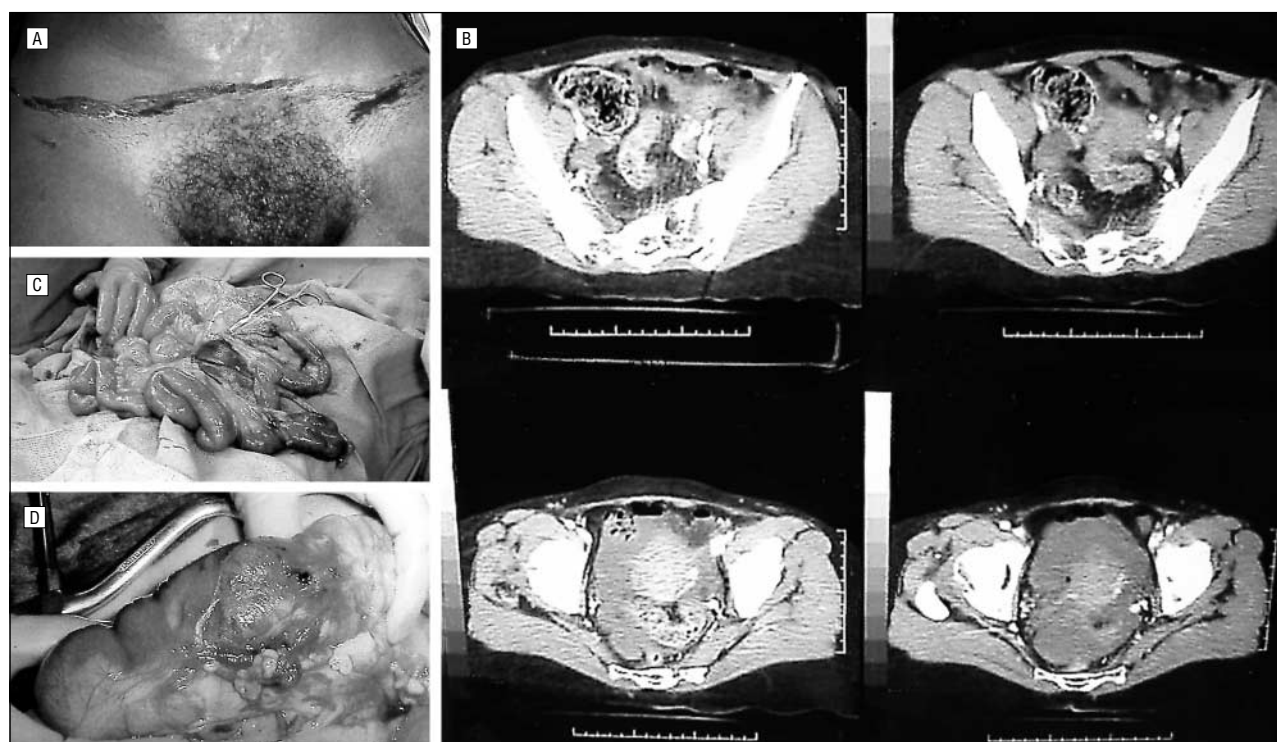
Patient with negative focused abdominal sonography for trauma scan result. A, Abdominal seat belt mark; B, computed tomographic findings—large free fluid without solid organ injury; C, operative findings—small-bowel mesenteric injury, compromised small bowel and ileal perforation; and D, operative findings—cecal deserosalization.
